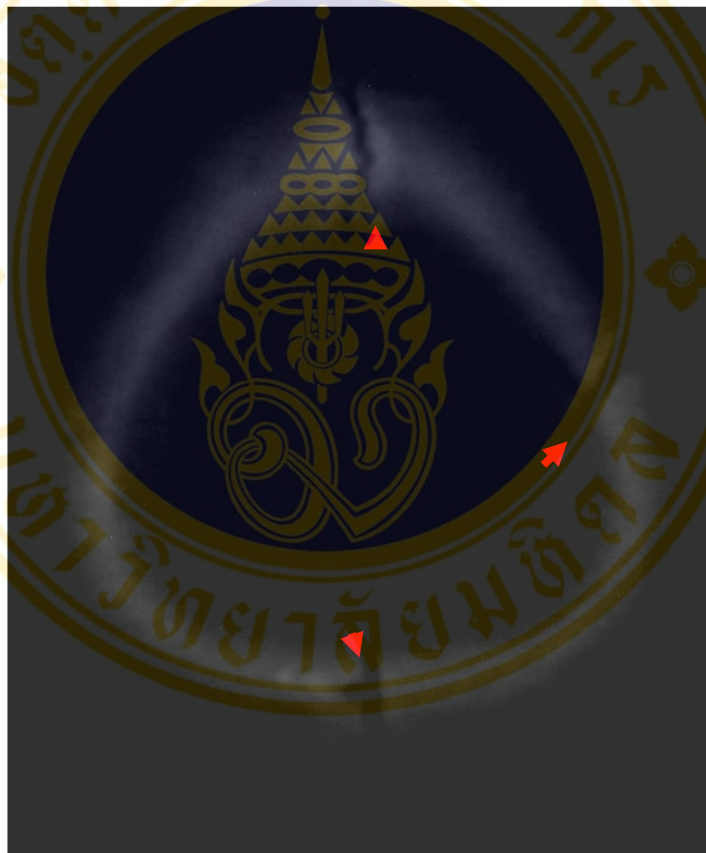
1 *Linear fractures in children: Skull radiograph (lateral projection)- Linear fracture is demonstrated in temporo-parietal bone (arrow). In pediatric populations, There are still persist of cranial sutures as sagittal suture in anterior and posterior aspect of cranial vault (arrowhead)*
